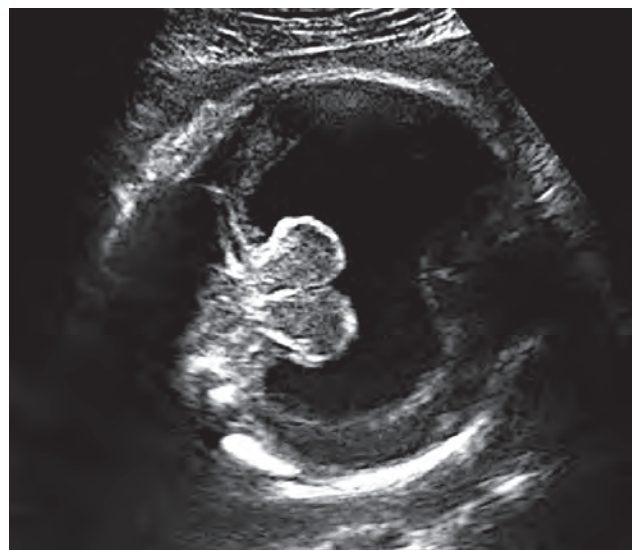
to C: Dandy-Walker malformation. (A) Axial plane of a 21-week fetal brain demonstrating moderately cystic dilatation of the posterior fossa communicating with the fourth ventricle. The aspect overlaps partially the vermian hypoplasia. Sagittal section by ultrasound or magnetic resonance imaging (MRI) makes the differential diagnosis; (B) fetal MRI in the sagittal plane. Elevation of the tentorium is visible, with mild vermian hypoplasia; and (C) fetal MRI in the transverse plane. A cross-section at this level shows an enlarged posterior fossa with a square shape. The vermis is not visible in this plane, as it is elevated
